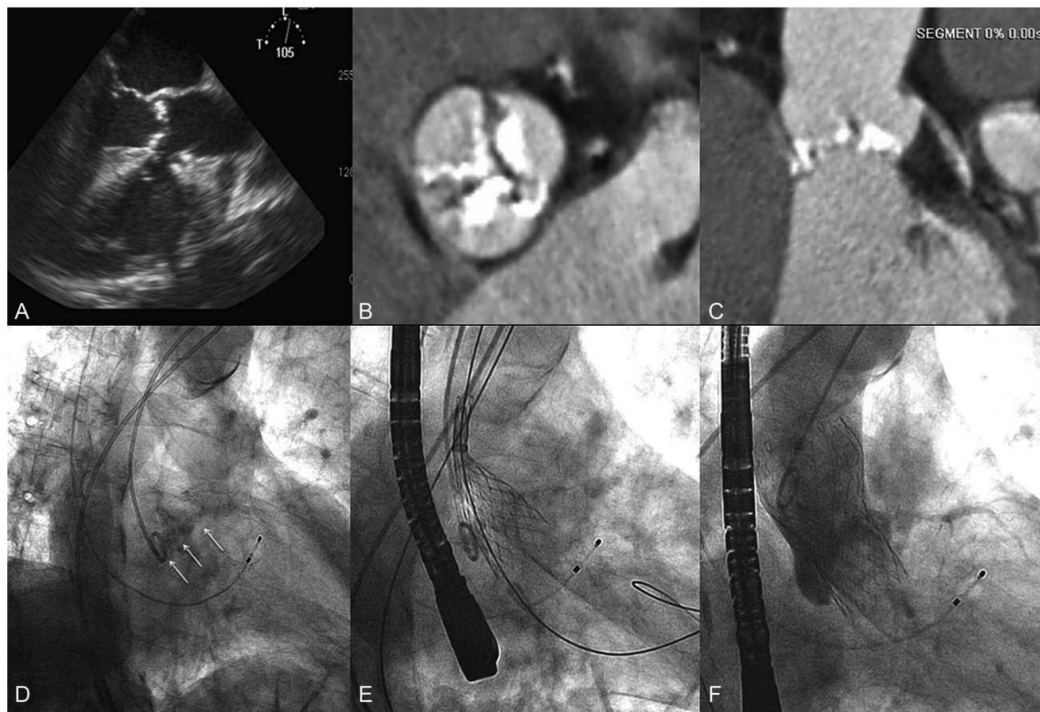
TEE sagittal image (A), coronal and transverse (B and C) cross-sectional CT images showing severe aortic valve calcification. Left oblique angiographic images: at baseline (D) showing severe calcification at the level of the aortic cusps (arrows), during (E) and after (F) direct CoreValve deployment. Note device placed at correct height without aortic regurgitation.
